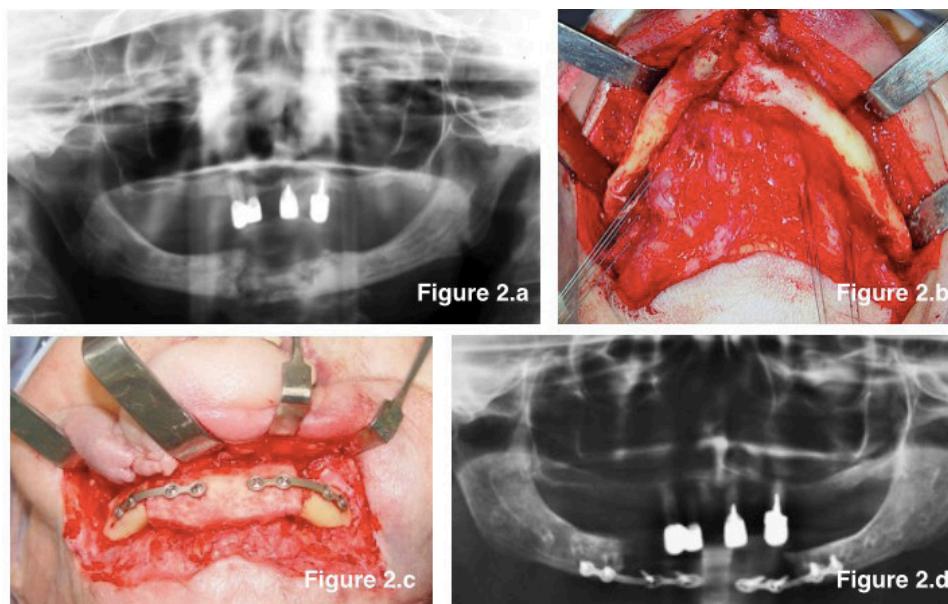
a) Radiograph showing a mixed sclerotic pattern and a fracture in the midline of the mandible; b) The fracture and necrotic area exposed during the surgery; c) Iliac bone graft fixed by plates and screws; d) Immediate post-operative radiograph
